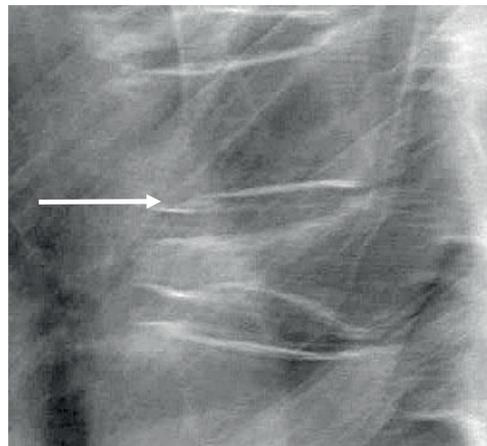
Lateral radiography showing a "step-like" or "step-off" endplate (arrow). An osteoporotic vertebral fracture is also visible one level below.
